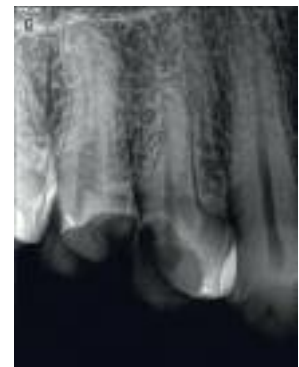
Radiograph taken after caries removal, showing close proximity of the cavity walls to the pulp, especially for tooth # 15
